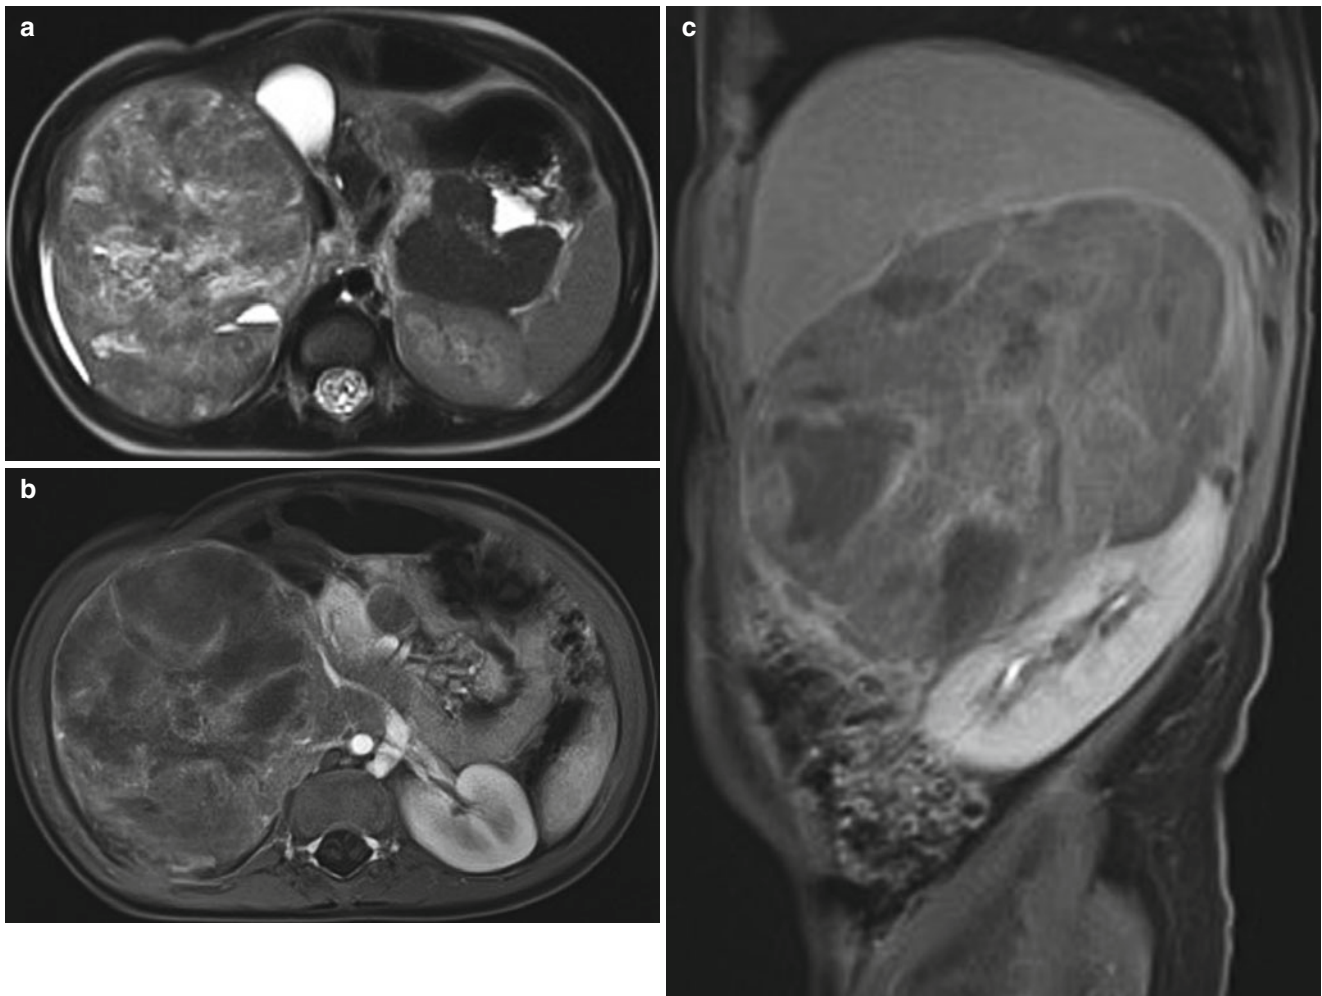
Right adrenal neuroblastoma in a 2-year-old boy. T2-weighted axial (a) and contrast-enhanced T1-weighted axial (b) and sagittal (c) MR images show a large right-sided adrenal neuroblastoma that crosses to the left of the midline, anterior to the aorta. The mass
